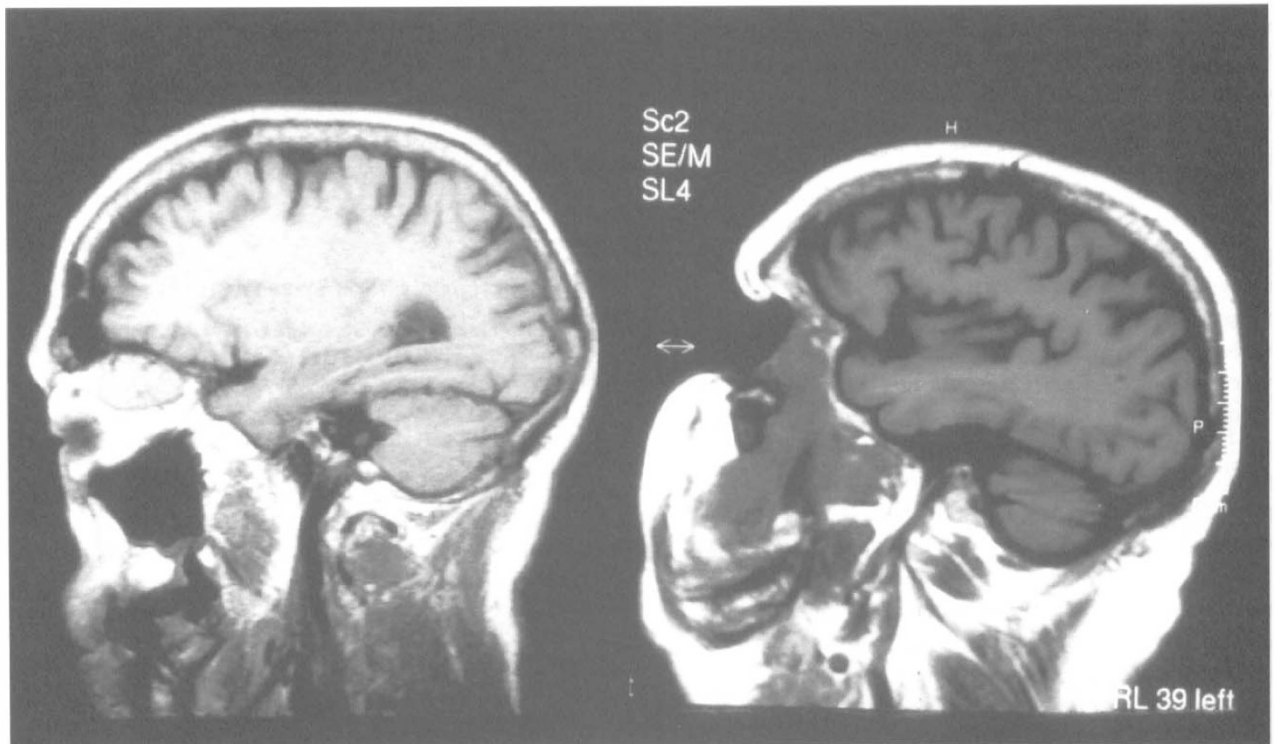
CT scan performed before exenteration (left) and extension of the tumour 38 months later (right).
